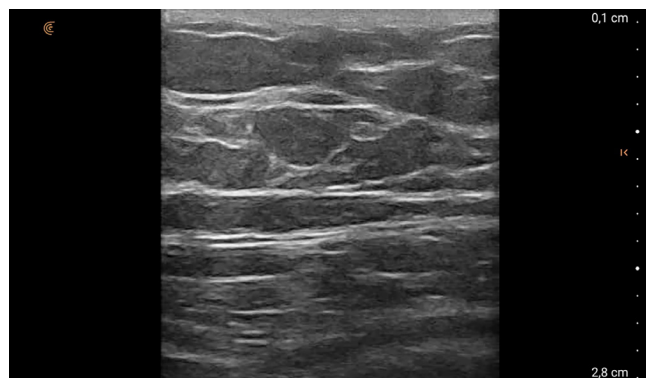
Breast ultrasonography of a patient presenting with complaints of female-type breast enlargement and diagnosed with gynecomastia.
